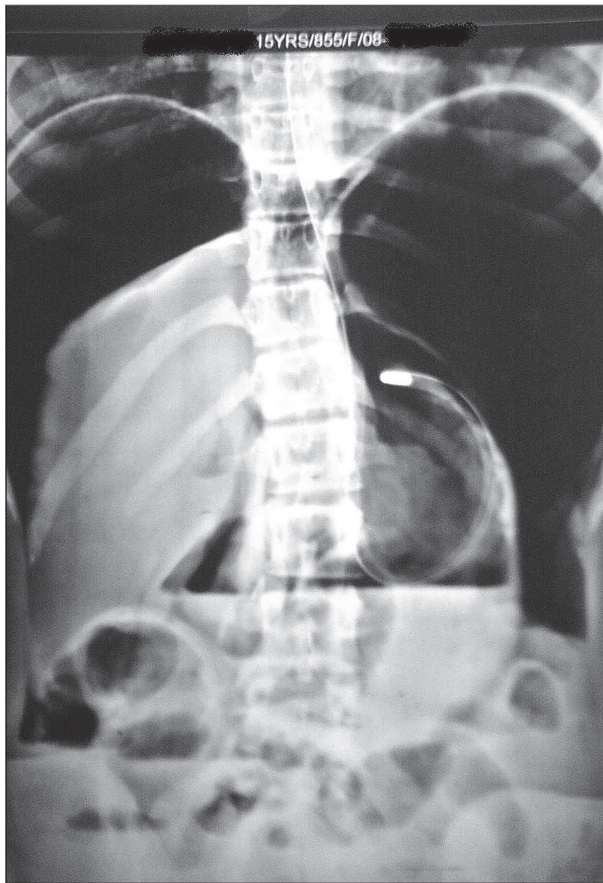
Erect X-ray abdomen showing massive pneumoperitoneum and air fluid levels
